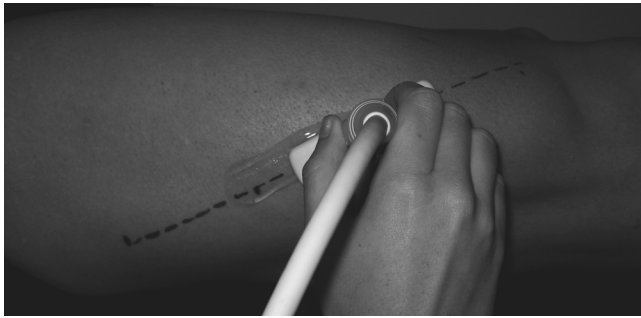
Measurement of vastus lateralis (VL) fascicle length (L_f). The black line marked on the skin is the line of orientation of VL fascicles, imaged by ultrasound.
